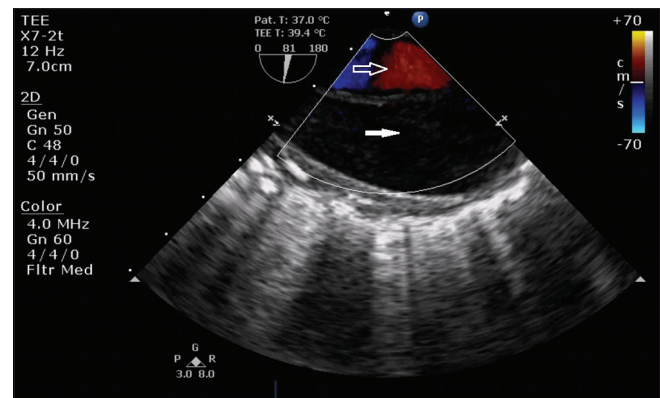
A color flow Doppler image of descending aorta LAX view showing systolic flow within the true lumen (black arrow) and no flow in the false lumen (white arrow)
